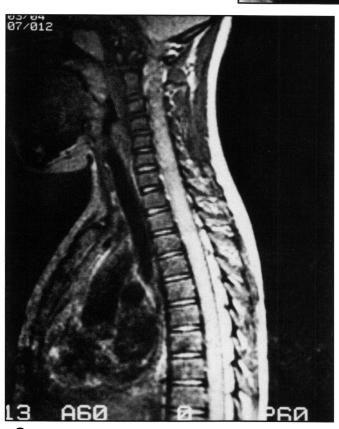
(c) — MRI (TR 1364, TE 35) cervical and thoracic spine showing diffuse enlargement of spinal cord from the level of C₃.
